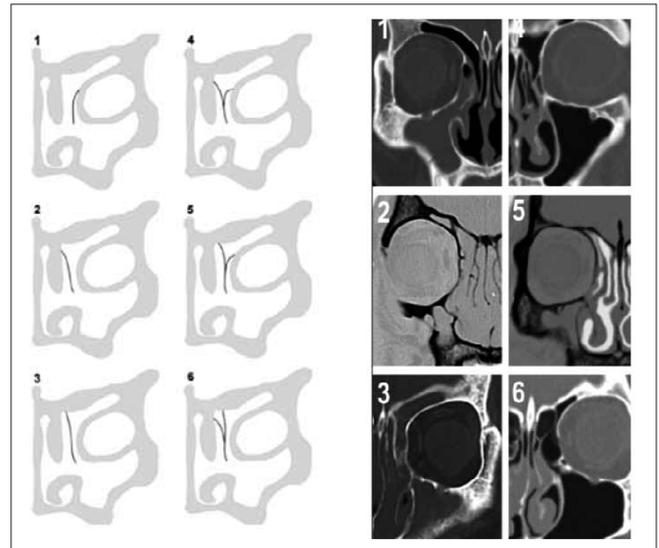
(Left half) Classification of uncinete process's superior attachment. 1: insertion into the lamina papyracea (type 1). 2: insertion into the middle turbinate (type 2). 3: insertion into the skull base (type 3). 4: insertion into both the lamina papyracea and the middle turbinate (type 4). 5: insertion into both the lamina papyracea and the skull base (type 5). 6: insertion into both the middle turbinate and the skull base (type 6). (Right half) Coronal CT scan could demonstrate each type of superior attachment of uncinete process.
